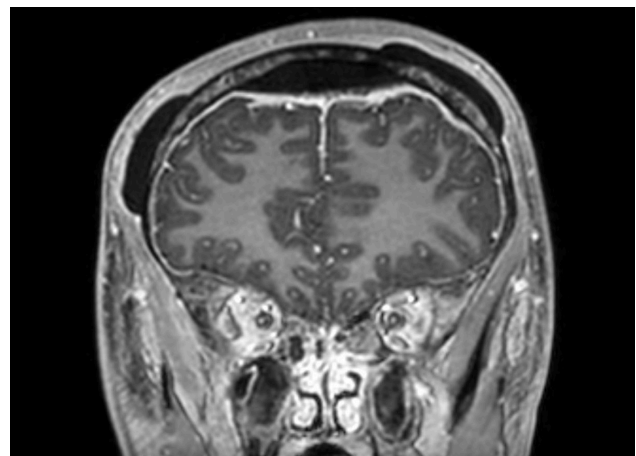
Magnetic resonance imaging at the time of admission (coronal image). It displays extradural and subperiosteal abscesses.
